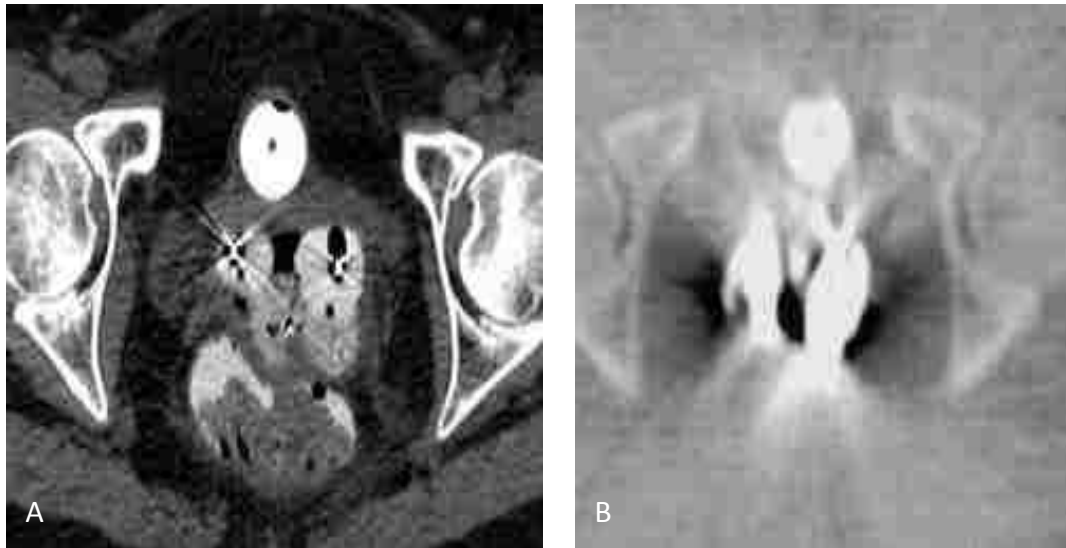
A transverse pelvic CT scan of typical patient anatomy with (A) an unshielded, CT/MR Fletcher applicators and (B) a tungsten shielded Fletcher applicator. For the CT/MR compatible applicator, minimal metal artifact can be seen from the source position markers within the ovoids when compared with the metal artifact present in the CT slice of the shielded Fletcher applicator. (Roeske, et al., 2003)
